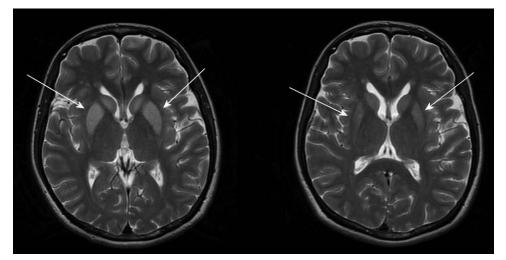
Left panel: Brain MRI revealed symmetric T2 hyperintensities of bilateral basal ganglia (white arrow). Right panel: Resolution of bilateral T2 hyperintensities (white arrow) 2 months later.
